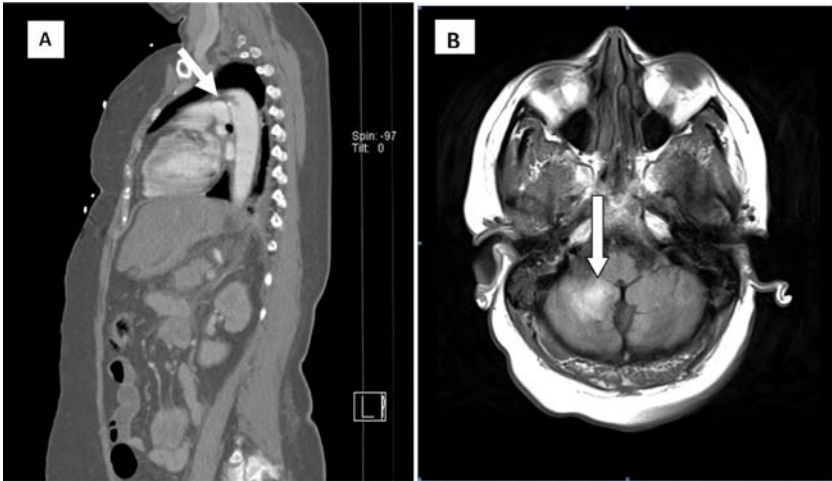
(A) CT angiogram showing aortic arch thrombosis. (B) MRI showing cerebellar infarction.
